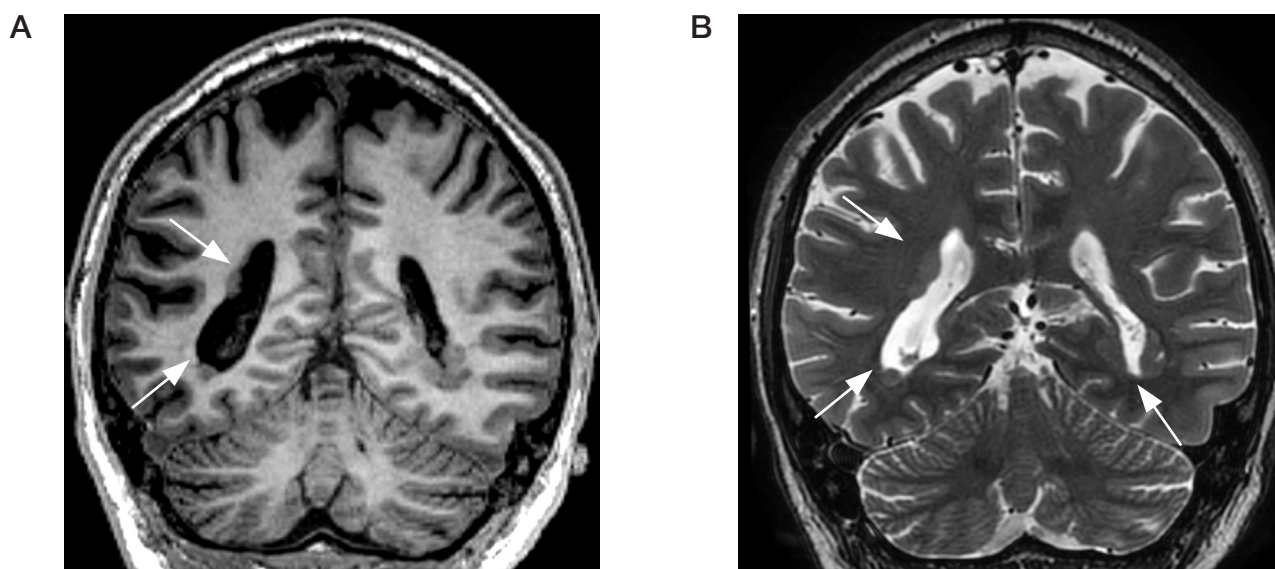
Brain MRI, oblique coronal scan, T1- (A) and T2-weighted images (B). Multiple areas of subependymal nodular grey matter heterotopia (arrows)
